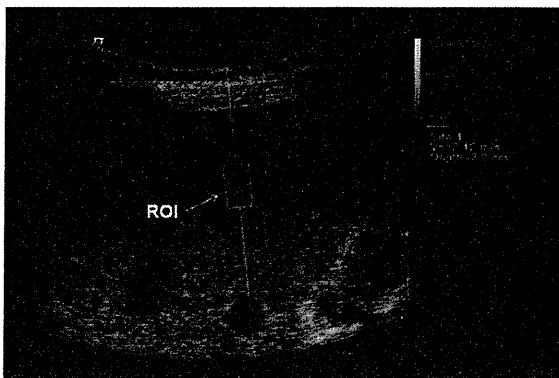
Acoustic radiation force impulse (ARFI) imaging on the 20th day of disease. The value of the shear wave velocity is 2.12 m/s. Sonogram shows the placement of the region of interest (arrow) for measurement of shear wave velocity at a depth of 2 cm from the surface of liver in segment 5, through the intercostal space.
